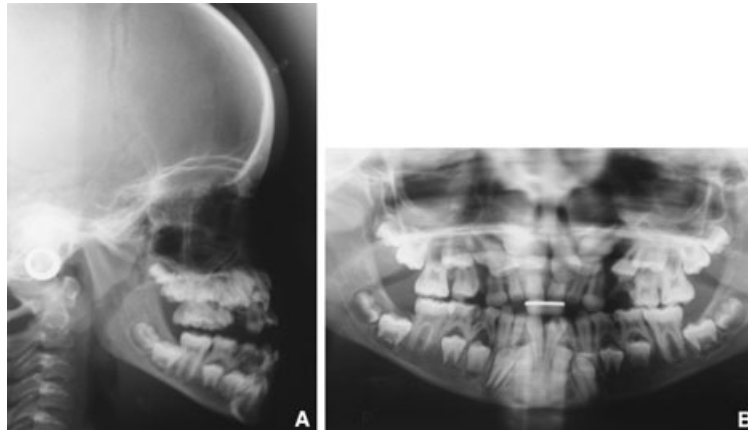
A 12-yr-old female patient with cleidocranial dysplasia. (A) Lateral skull radiograph showing a wormian bone in the temporal suture region and a hypoplastic maxilla. (B) Panoramic radiograph showing supernumerary and unerupted teeth, some of which are ectopic. Typically, the lower permanent central incisors and all four first permanent molars have erupted.
